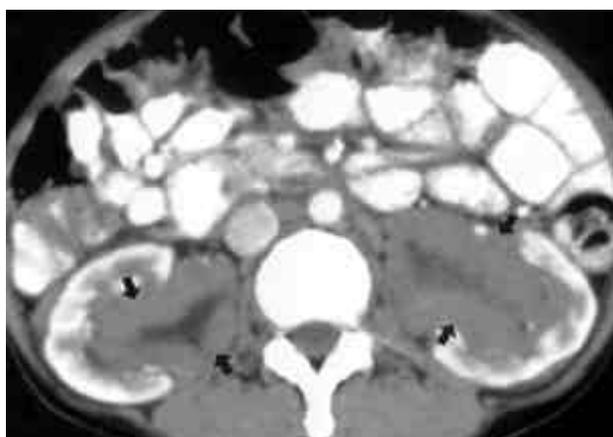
Enhanced CT scan shows lobulated masses with widening and filling of pelvocalyceal systems with homogeneously mild enhancement (arrows).
